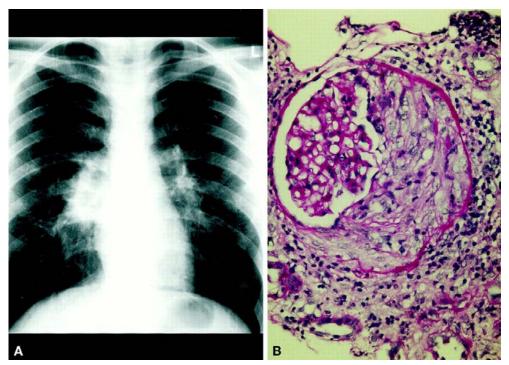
(A) Roentgenogram showing bilateral hilar adenopathy in a patient with sarcoidosis. (B) Extracapillary glomerulonephritis with crescent formation. Magnification, x500 (periodic acid-Schiff). Gobel U et al. JASN 2001; 12:616-623
